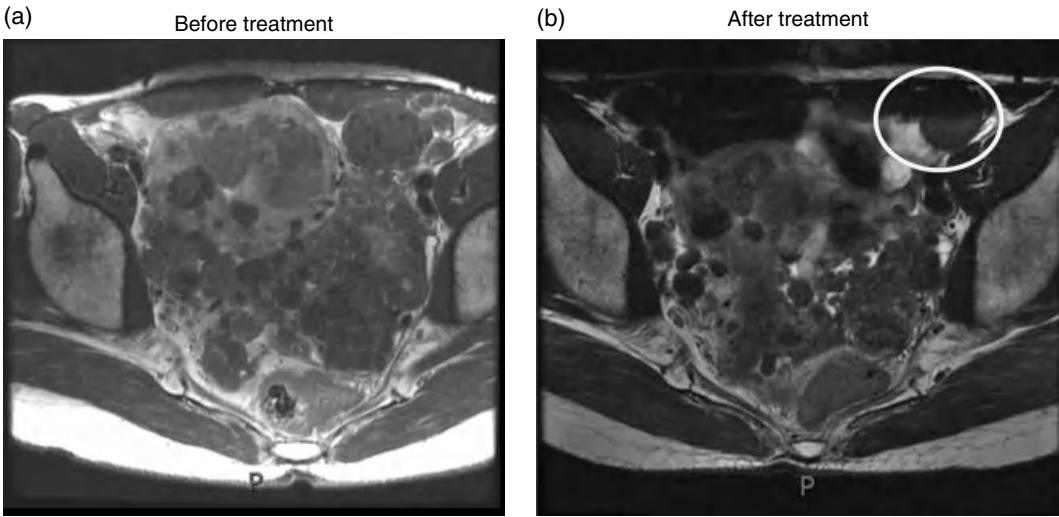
BML uterine lesions before and after leuprolide treatment. (a) MRI of pelvis before treatment. (b) MRI of pelvis demonstrating reduction in size of a circled lesion after treatment with the GnRH agonist, leuprolide.
